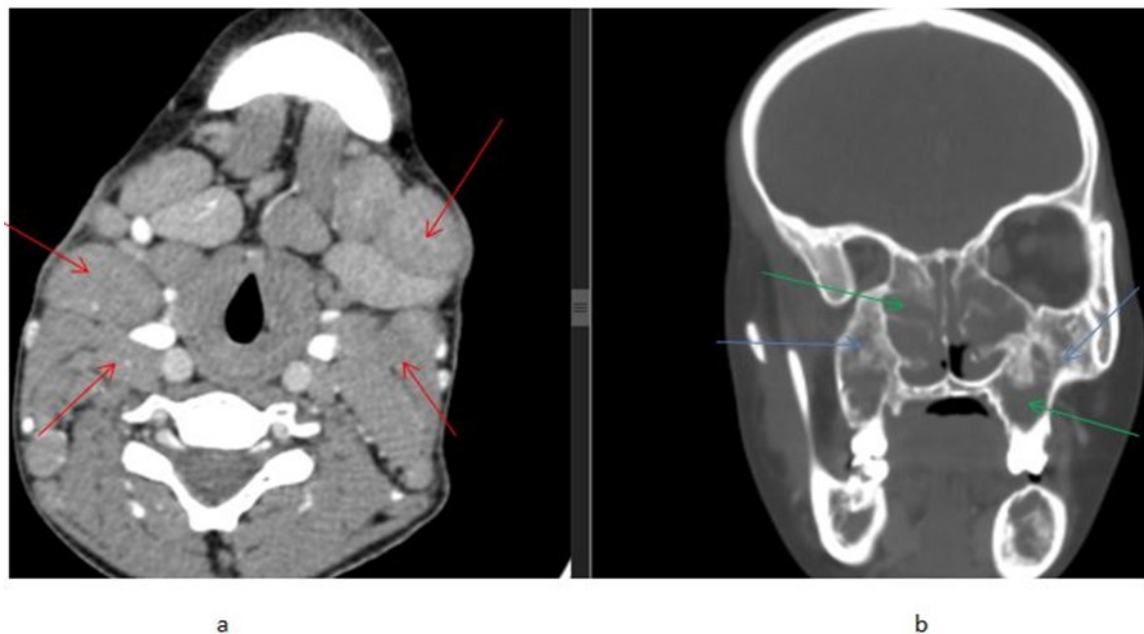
Head and Neck CT (a) axial soft tissue window show bilateral different sized numerous enlarged cervical lymph nodes (red arrows). (b) Coronal plane bone window show opacification of maxillary and ethmoid sinuses (green arrows) and lytic change of maxillary bone (blue arrows).
